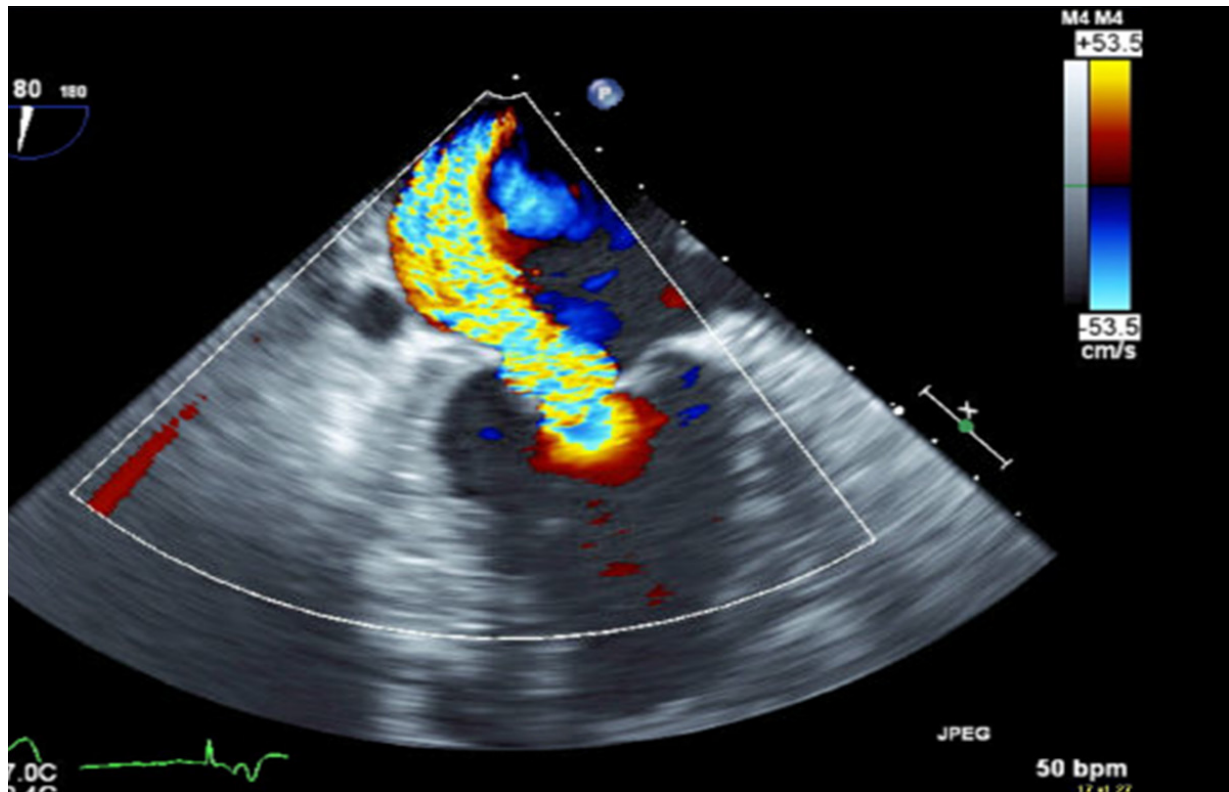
A preoperative transesophageal echocardiogram shows a regurgitant jet that was primarily central and secondary to a dilated annulus. This was addressed with an annuloplasty. There was also a smaller eccentric jet at A2 and P2 as a consequence of mild anterior leaflet prolapse, which was addressed with an edge-to-edge stitch.
